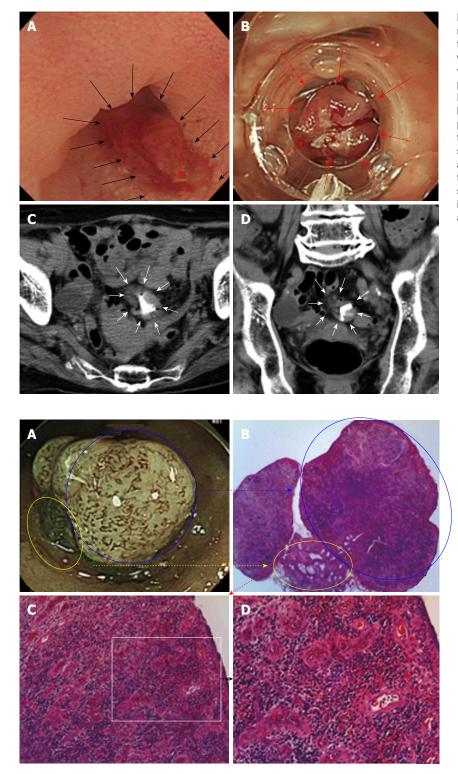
Closure of the diverticulum using the resected stalk of the polyp. A: In a closer view of the resected surface, the cavity of the diverticulum was irregular (the black arrows), and an exposed vessel was identified (red arrow); resection of the polyp indicated that it arose from the diverticulum; B: To prevent bleeding and delayed perforation following the endoscopic mucosal resection (EMR) procedure, we inverted the diverticulum and sutured the inverted diverticulum, including the resected stalk of the polyp, using an over-the-scope clip (red arrows); C, D: After the EMR procedure, computed tomography was performed to examine the soft tissue density around the over-the-scope clip and the increased fat density around the resected site (white arrows).
